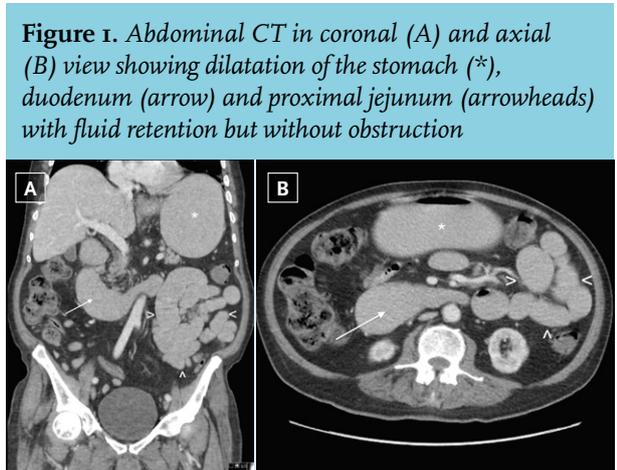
Abdominal CT in coronal (A) and axial (B) view showing dilatation of the stomach (*), duodenum (arrow) and proximal jejunum (arrowheads) with fluid retention but without obstruction
